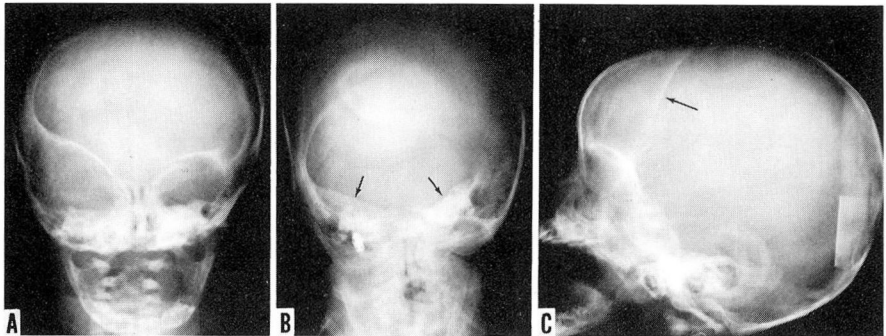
Case 2. Preoperative roentgenograms: A, elliptic or teardrop right orbit is well demonstrated; there also is a mild but definite tilting of the nasal septum to the same side. B, the right petrous ridge is depressed as compared with the opposite side (arrow). C, only the left coronal suture can be seen (arrow).
